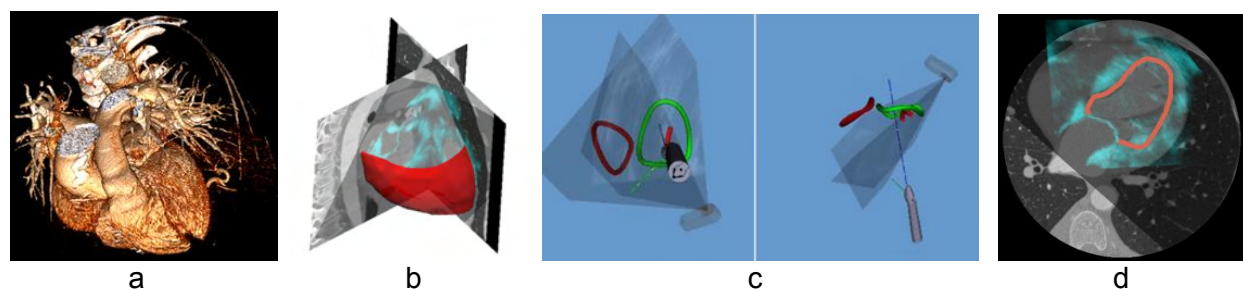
Different visualization options: a) volume rendering, b) fused CT, US, and models from CT c) selected anatomy from CT fused with US d) direct overlay of CT and US
